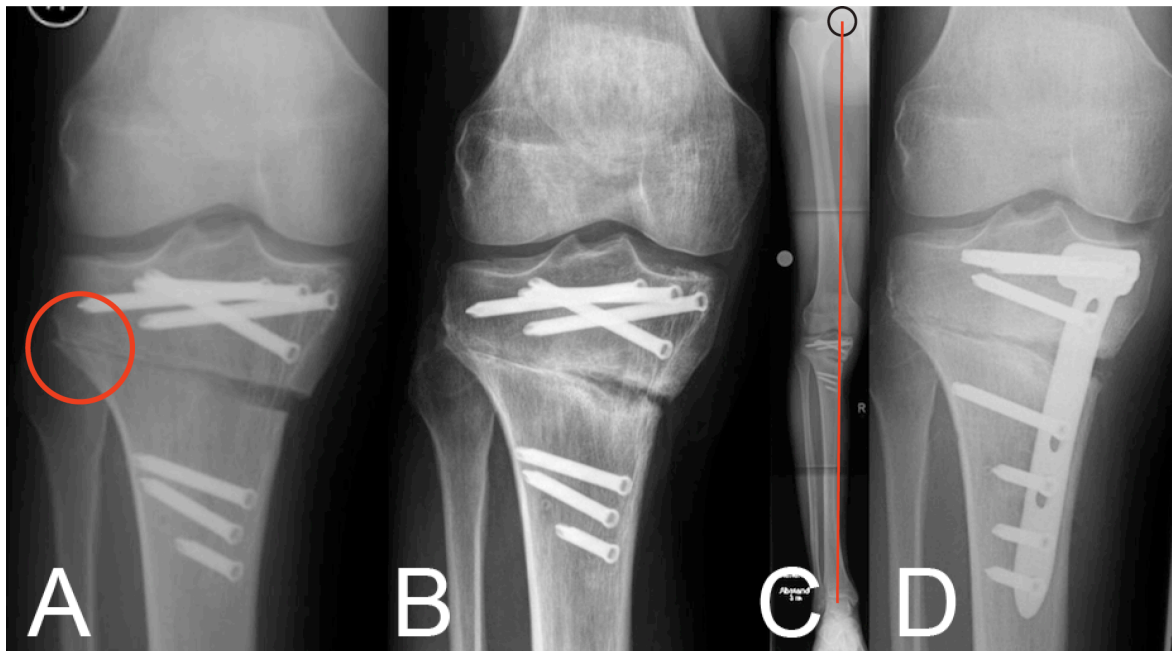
Postoperative AP radiograph at the inpatient stay show a completely sawed lateral cortex with a remaining lateral gap (red circle) in a 42 year old male non-smoker (BMI: 23 (kg/ m²)) (A). A non-union with persistent pain was diagnosed nine months after ow HTO with the 2nd generation PEEKPower HTO-Plate® (B). On the postoperative AP long-leg weight bearing radiograph a medial deviation of the mechanical axis (red line) from the center of the knee was observed (C). This disagreed the preoperative planning. The PEEKPower HTO-Plate® was replaced by the TomoFix™ plate and the mechanical axis was corrected (D). The osteotomy gap in this patient was successfully filled with autologous cancelous bone from the iliac crest. In this patient removal of the TomoFix™ plate within complete consolidation of the osteotomy gap was not done until today.
